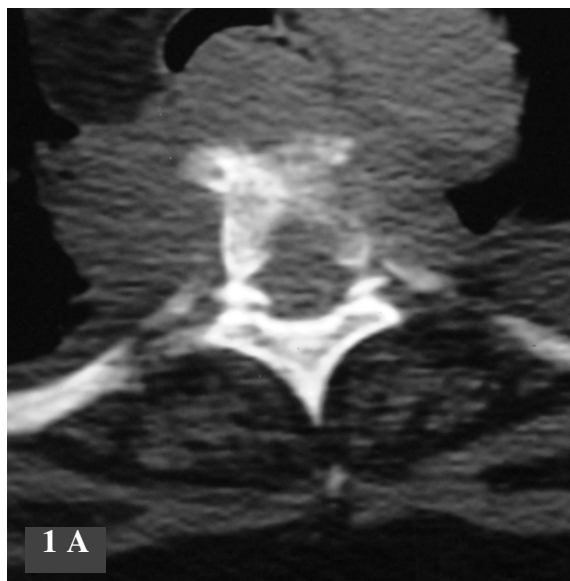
A and 1 B. Axial scans from a thoracic spine CT with intrathecal contrast demonstrating a prevertebral soft tissue mass with vertebral body bone destruction and epidural extension of tumor. Bilateral pleural effusions are present. There is narrowing and encasement of bilateral mainstem bronchi. Abnormal soft tissue also surrounds the descending aorta.
